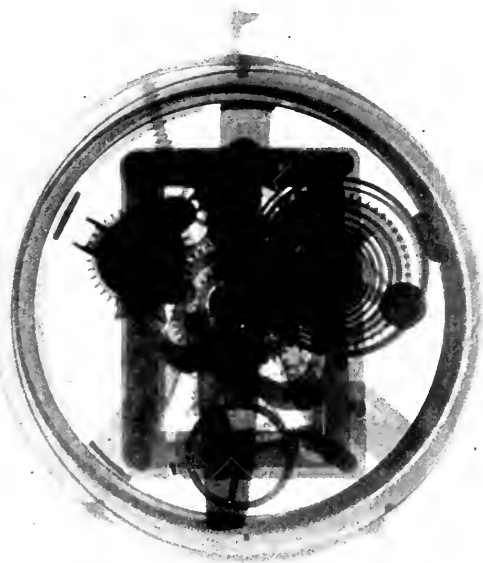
Alarm clock radiographed in its case.
